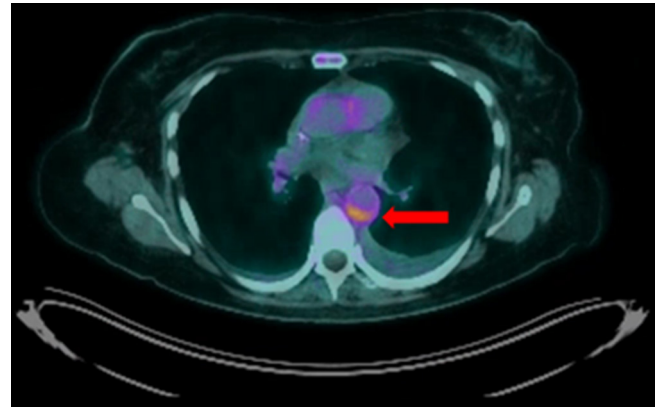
Fused axial ¹⁸F-FDG PET-CT shows increased FDG avidity in the aortic wall corresponding to the mural thickening (red arrow). FDG, fludeoxyglucose.
